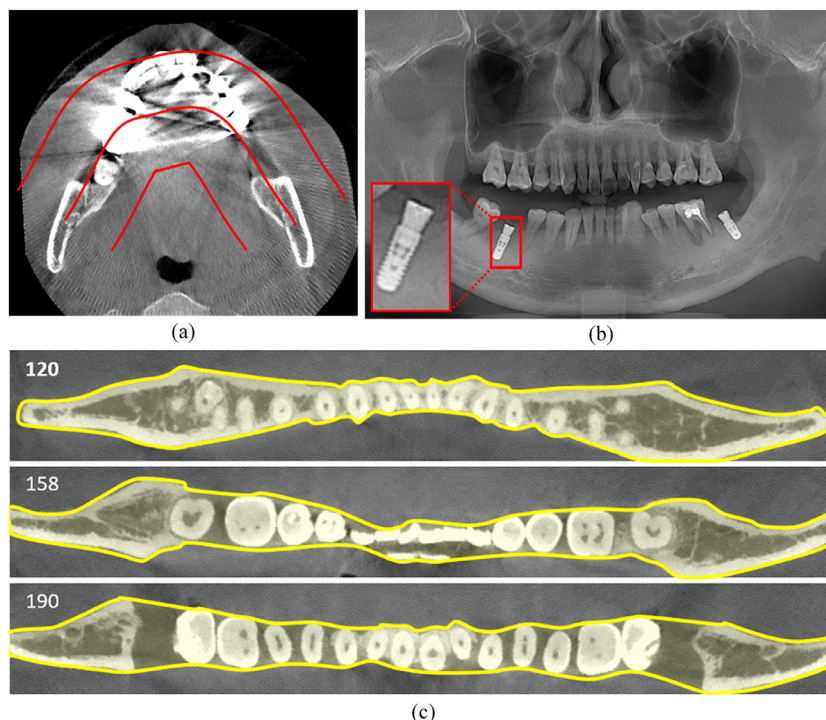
(a) Dental arch thickness and dental arch detection results of severe metal artifact CBCT data. (b) Halo artifacts in panoramic image. (c) ROIs (yellow region) in different slices of the curved MPR image set.
